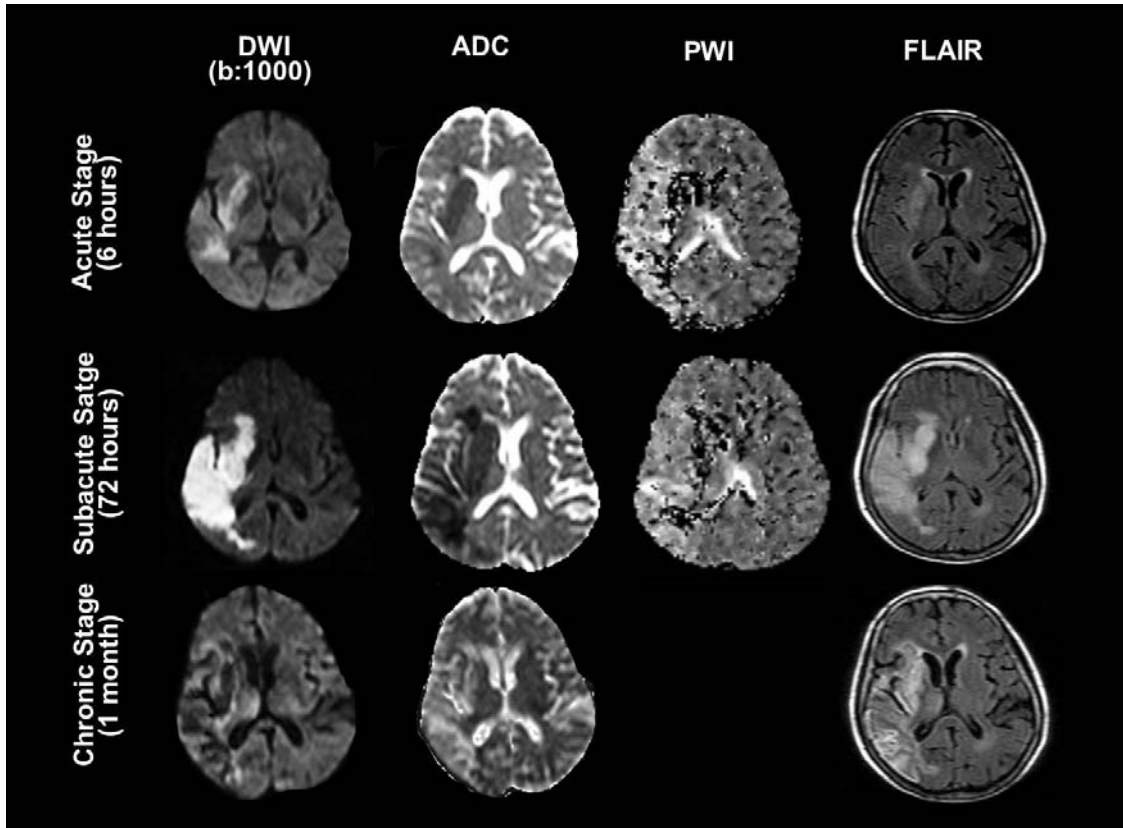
MRI protocol. A 67-year old man with acute right-sided striatocapsular and peripheral middle cerebral artery infarction (seen on DWI images at 6 hours after clinical onset). Perfusion maps reflect hypoperfusion on large area of superficial peripheral territory. Slightly increased signal intensity is shown on FLAIR at 6 hours and markedly increased at 72 hours. A DWI-FLAIR mismatch in acute phase is demonstrated in this case. The infarct volume increased at 72 hours leading to large lesion on deep and peripheral middle cerebral artery territories. Note: The standard MR imaging protocol in acute stroke also includes other sequences, such as T2 gradient echo and angiography (not seen in this figure) in order to exclude cerebral hemorrhage and vascular occlusion, respectively.
